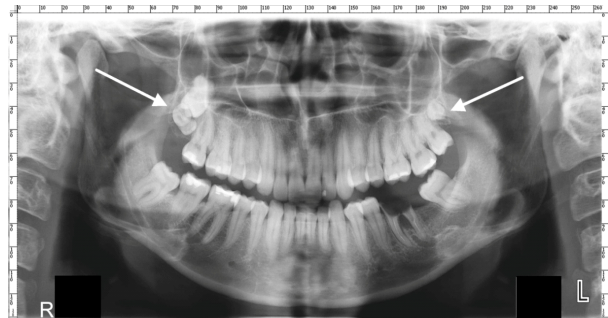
Panoramic radiological investigation showing the presence of three distomolars in the upper jaw. R: Right; L: Left.
